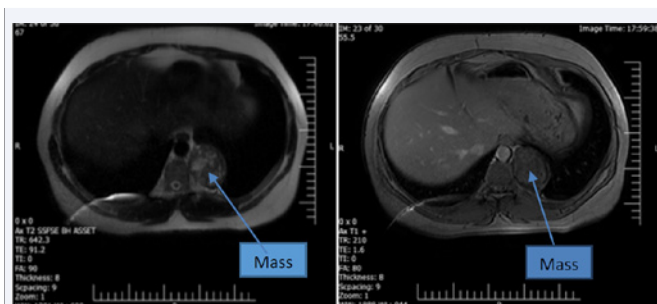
The MRI of the chest showed a well defined, encapsulated, multiseptated, heterosignal mass measuring about 81 x 68mm within the left paravertebral and paraaortic space and Extending beneath the T10, Pushing the Pleura and the Lung Inwards.
